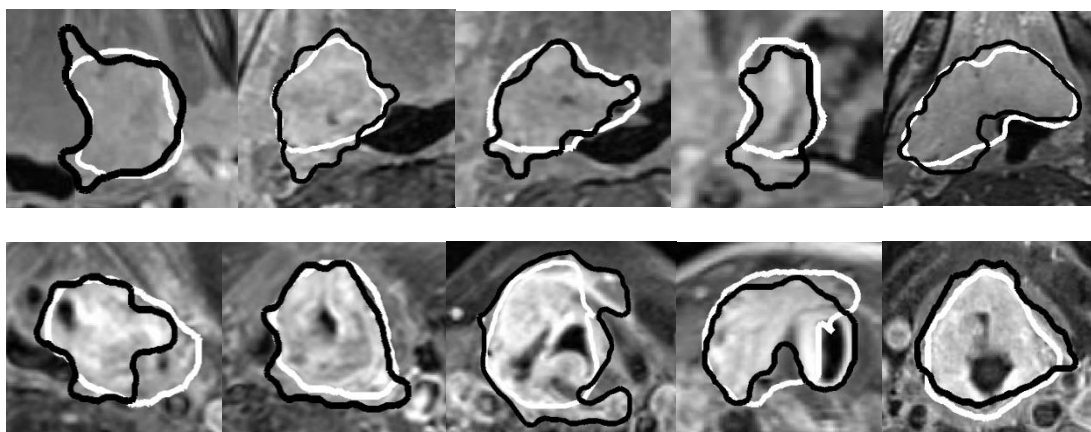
10 axial MRI slices from different patients demonstrating acceptable agreement (DSC: $0.7-0.85$) between C-auto (black outline) and C-gold (white outline) tumour outlines
